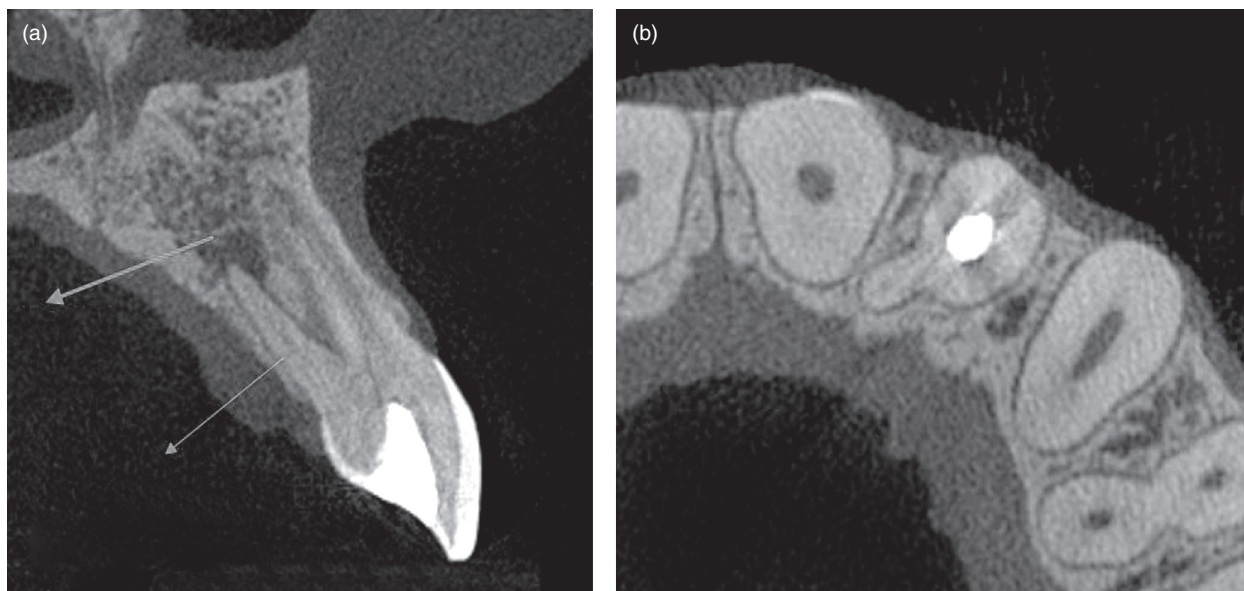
Cone-beam computed tomography. (a,b) Scans showing the extra root at palatal level with associated apical periodontitis
